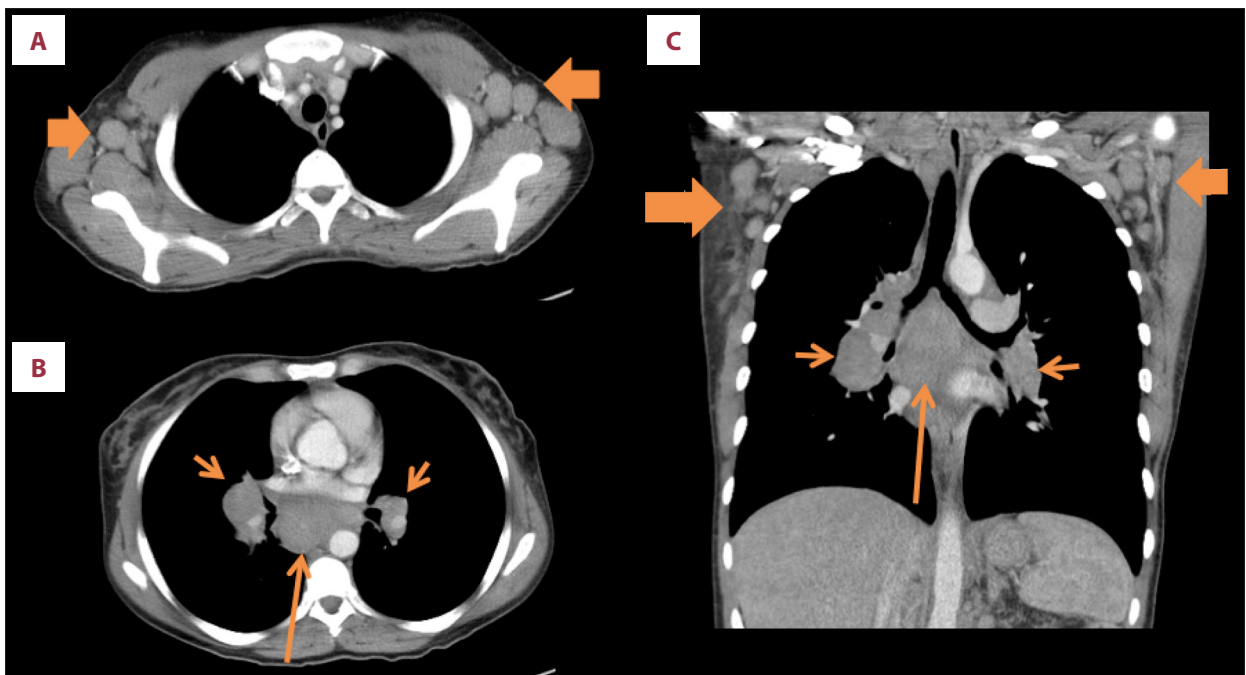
At Presentation, selected axial (A, B) and coronal (C) images from contrast-enhanced CT scan of the chest, demonstrating bilateral axillary (thick arrows), subcarinal (long arrows), and right hilar larger than left (short arrows) lymphadenopathy.
